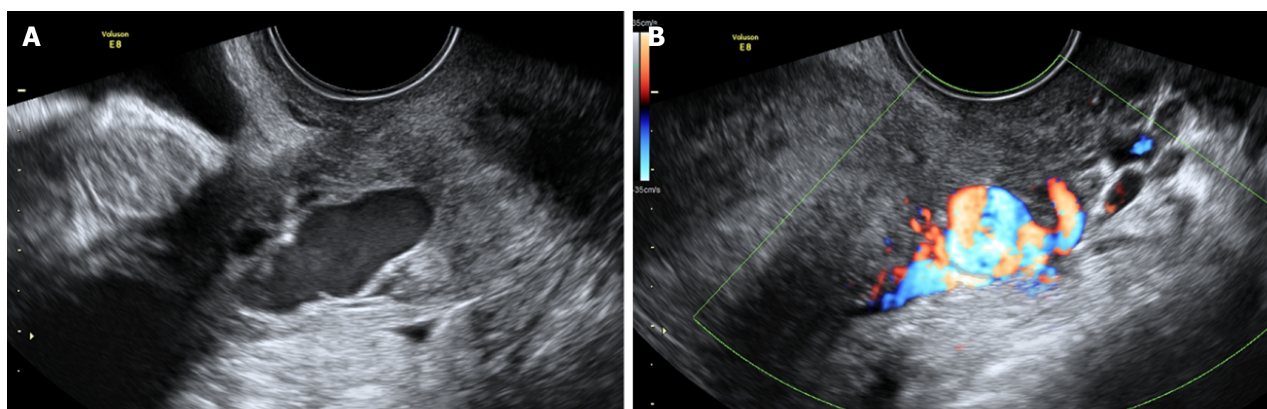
Transvaginal ultrasonography. A: A 3-cm echo-free space is evident in the right wall of the uterus; B: Color Doppler reveals abundant blood flow at the same site.
